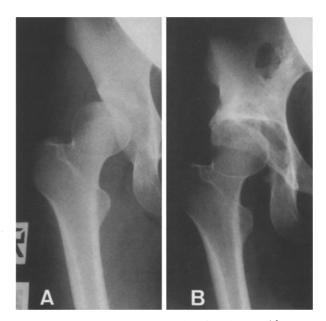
Radiographs of the hip of a 21-year-old woman. A Before operation; B Three and a half years after operation. The femoral head is displaced laterally because insufficient bone has been resected from the osteotomy site
